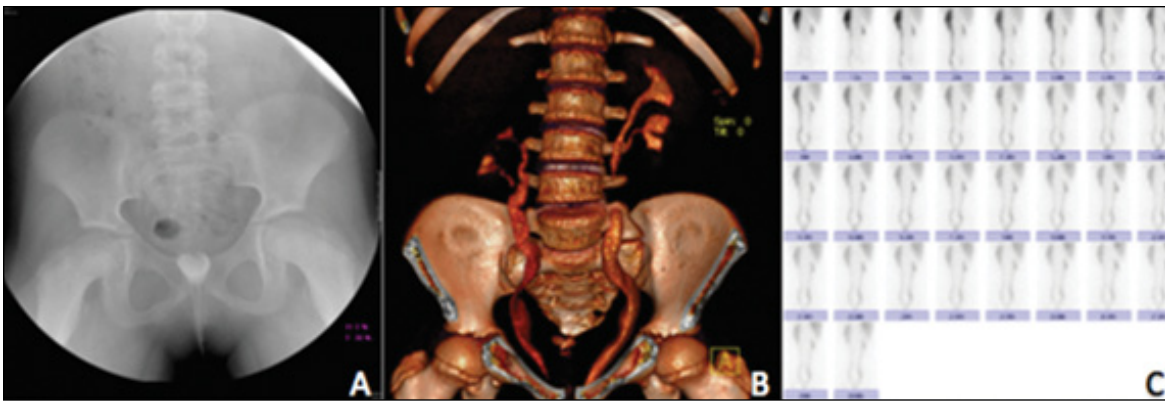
A: Voiding cystourethrography, bladder absence. B: computed tomography urograph, bilateral incomplete kidney duplication, ectopic right kidney, bladder absence. C: renal scintigraphy MAG-3, bladder absence.
